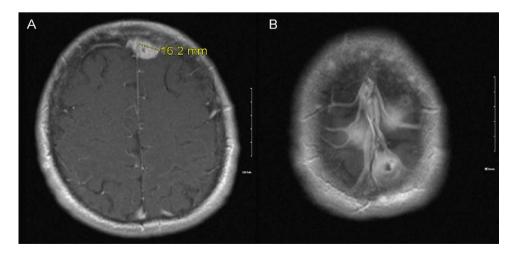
MRI post-contrast coronal spin-echo, inversion recovery and diffusion-weighted images obtained through the brain. (A) A 16.2 mm diameter dural-based mass at the junction of the high left anterior convexity and falx cerebri. (B) Three dural-based masses at the cerebral vertex: 17 mm (right-sided), 16 mm (left-sided anterior), and 17 mm (left-side posterior). These three lesions were immediately adjacent to the superior sagittal sinus but did not appear to invade the sinus.
